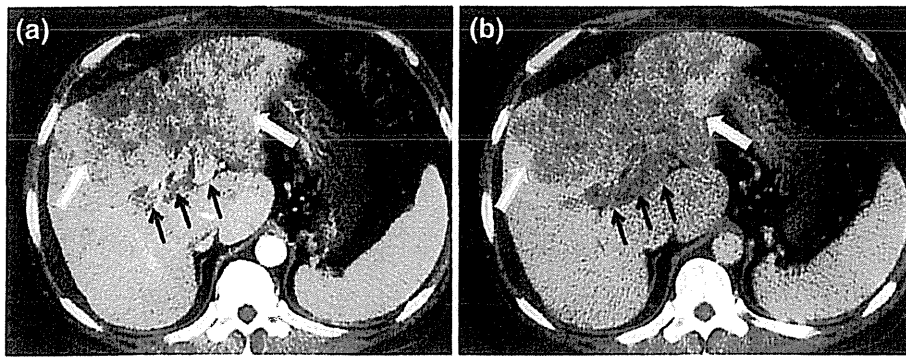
Contrast-enhanced computed tomography scans obtained before therapy for a 48-year-old man with high serum vascular endothelial growth factor level and advanced hepatocellular carcinoma who was classified as having progressive disease after hepatic arterial infusion
